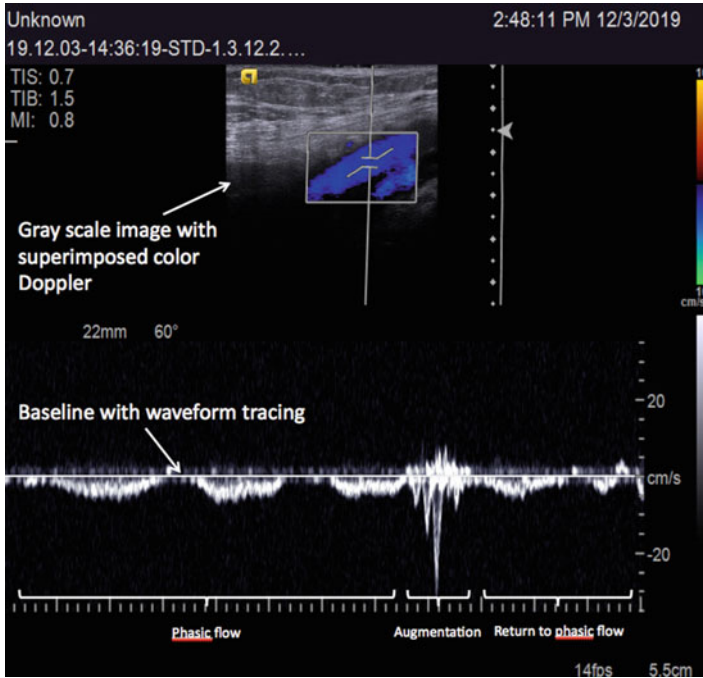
Evidence for augmentation of venous return in the popliteal vein obtained with spectral Doppler. The gray scale image of the popliteal vein with superimposed color flow Doppler appears in the top half of the image. The position of the gate in the lumen of the vein shows where the velocity measurement is made. Blood flow is shown as a waveform tracing relative to the baseline (lower half of the image). The waveform tracing below the baseline indicates flow away from the transducer and towards the heart. A waveform tracing above the baseline would indicate retrograde flow toward the transducer. The waveform tracing plots blood flow velocity in cm/sec on the y-axis and time on the x-axis. Blood in the popliteal vein is returned to the trunk at a low velocity (about 5 cm/s) in a waveform depicting phasic flow. During augmentation, there is a rapid increase in velocity to 25 cm/s, followed by a return to phasic flow
